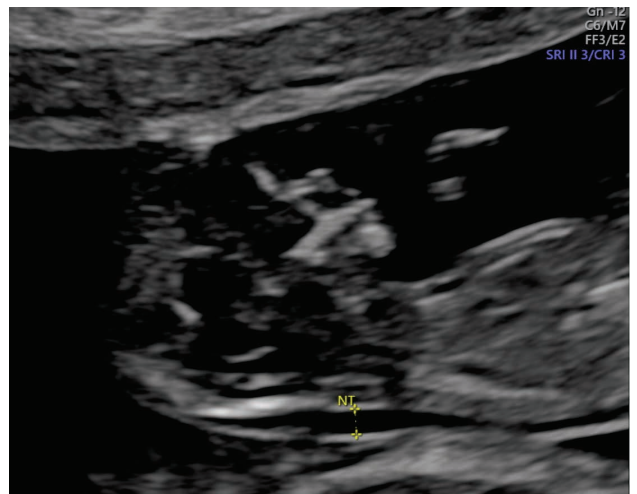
Ultrasound measuring of fetal nuchal translucency on sagittal standard section: 2.50 mm at 13 weeks of gestation
